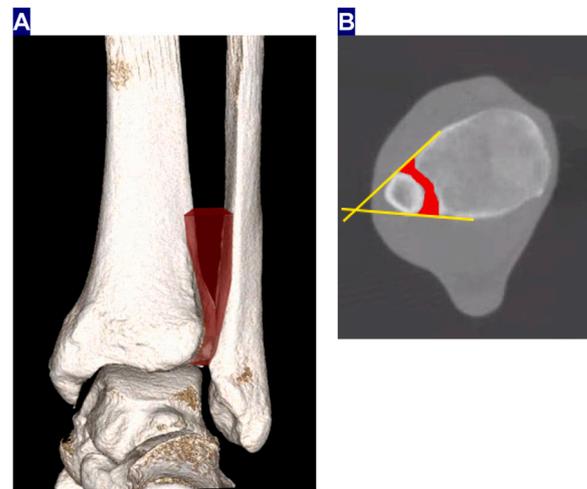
Weight-bearing CT scan measurements of the volume and area of the distal tibiofibular joint.
